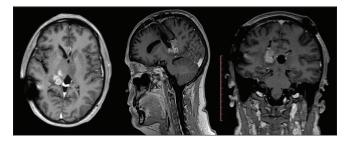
Magnetic resonance imaging with gad, 12 months after the operation.
